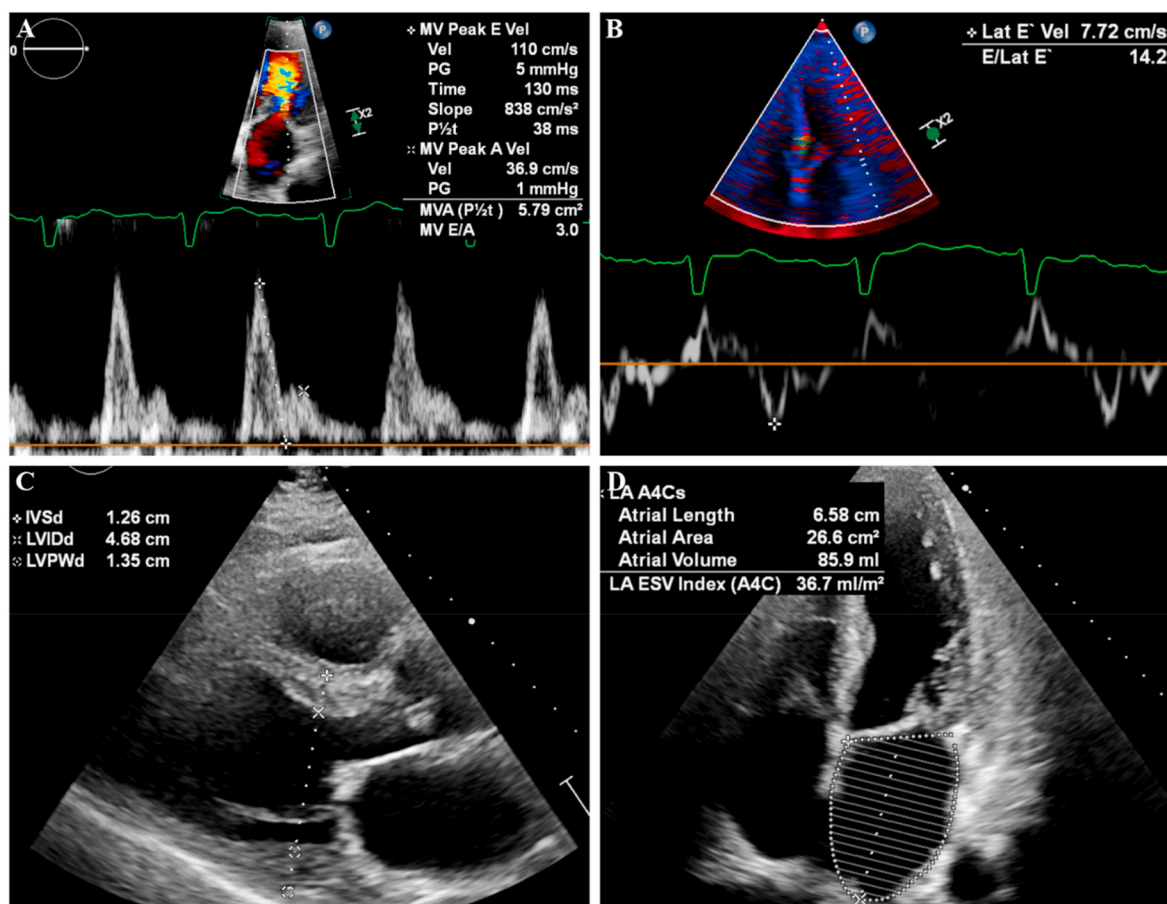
Transthoracic echocardiographic findings. Pulsed-wave Doppler interrogation of the mitral inflow velocities showing restrictive filling pattern with elevated early diastolic to late diastolic peak velocity ratio (E/A) and short deceleration time (A). Lateral mitral annulus tissue Doppler demonstrating reduced early diastolic velocity (e') and elevated E/ e' ratio (B). Increased left ventricular wall thickness is demonstrated in the parasternal long-axis view (C). Atrial enlargement is evident in the apical 4-chamber view (D).
